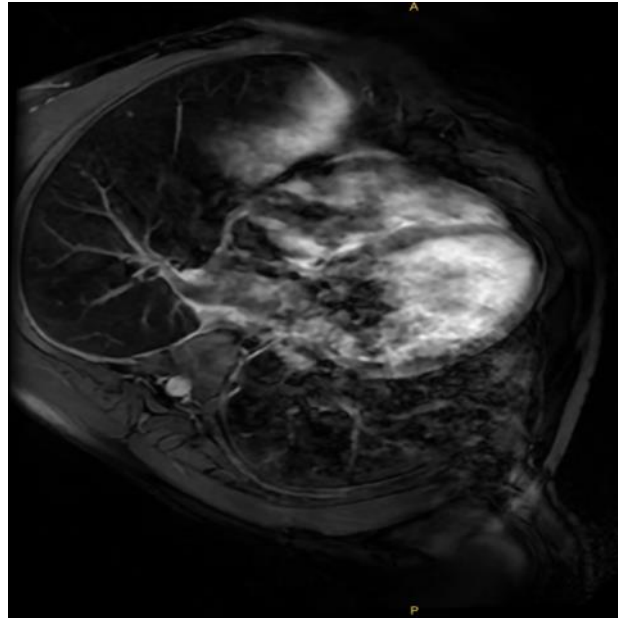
Cardiac magnetic resonance imaging: Dilated cardiomyopathy with severe systolic dysfunction (LVEF 15%). Normal-sized right ventricle with systolic dysfunction (RVEF 42%). Severe diffuse hypokinesis. Eccentric hypertrophy. Diffuse right ventricular hypokinesis. Left atrial dilation. Non-ischemic late gadolinium enhancement was observed in the anterior, anterolateral, and inferior walls of the left ventricle with edema on STIR sequences, with an ER (edema ratio) greater than 2. Tissue characterization by T1, T2, and ECF mapping showed increased T1, T2, and ECF values in areas of edema. Epicardial late gadolinium enhancement was also observed in the right ventricular free wall, findings consistent with acute myocarditis. Mild global pericardial effusion without hemodynamic compromise. Mild bilateral pleural effusion. The study was performed in the presence of atrial fibrillation
